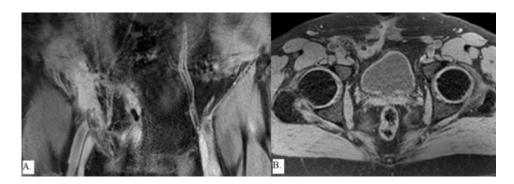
MRI aspect of parietal suppuration following TAPP hernia repair. 2A. Collection in the right inguinal region.2B. Fistula tract from the collection to the skin in the hypogastric region
